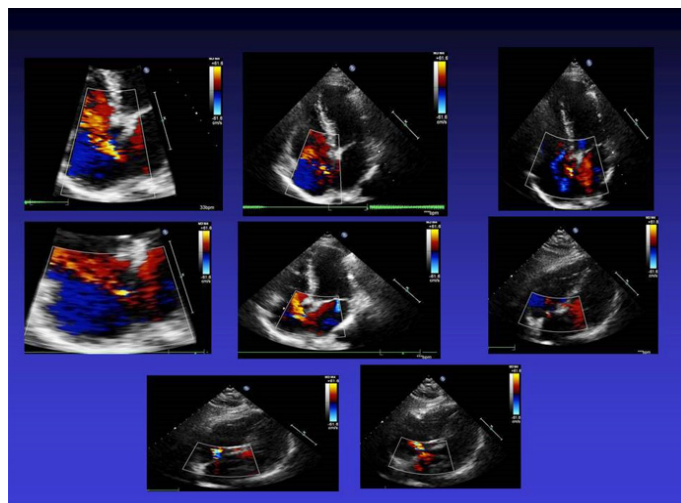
Echocardiographic picture of the patient seen in transthoracic echocardiography. The explanations in the text.
